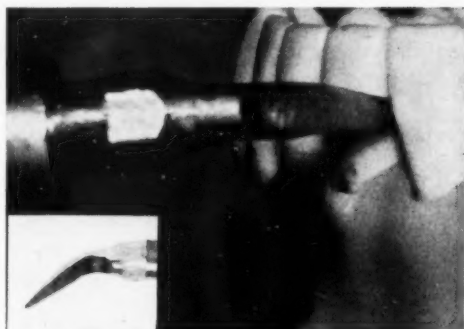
Ultrasonic scaling point no. 1
